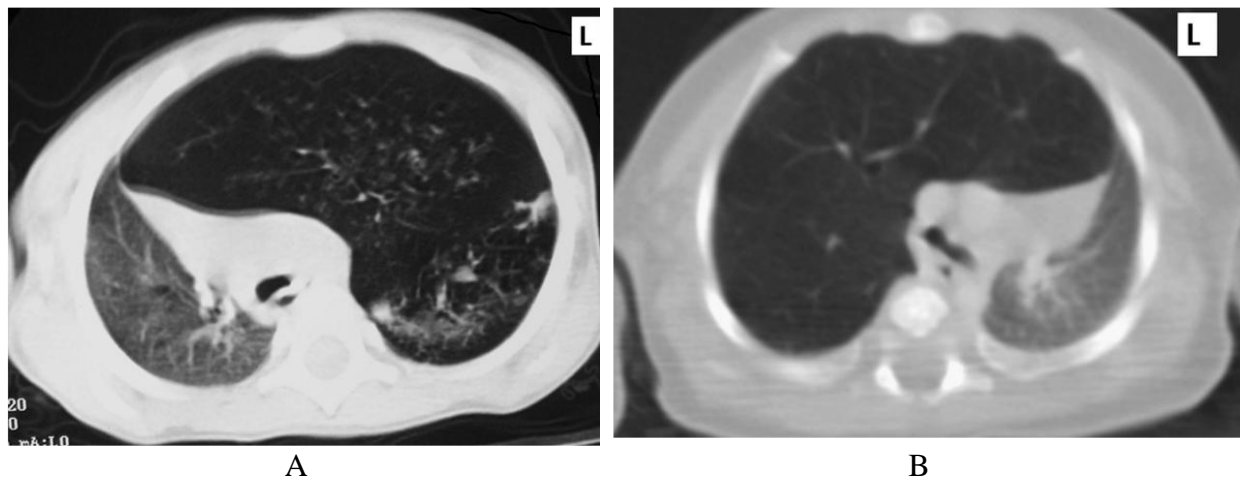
Computed tomograms showing congenital emphysema of S₁–S₃ of the left upper lobe (A) and right upper lobe (B). Affected lung tissue is overinflated, with a reduced vascular pattern, cardiac shift to the contralateral side and a large mediastinal hernia. The trachea is narrowed and displaced above its bifurcation.
